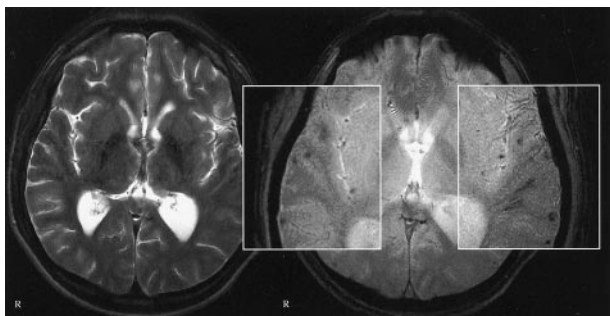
Images of a 22-year-old man who was the driver of a car that collided with a truck in June 1999. Multiple traumatic microbleeds are shown at the gray matter-white matter border. *Left*, T2-weighted image; *right*, T2*-weighted image. Images were obtained in the same plane. GCS score, 5; GOS score, 4.
